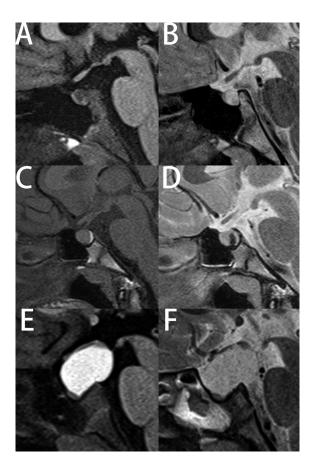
Representative images of the three magnetic resonance imaging signal intensity patterns observed in pediatric patients with Rathke's cleft cysts: T1 weighted image (WI) hypointensity (A) and T2WI hyperintensity (B) (Case 1); T1WI isointensity (C) and T2WI hypointensity (D) (Case 3); and T1WI hyperintensity (E) and T2WI isointensity (F) (Case 5).
